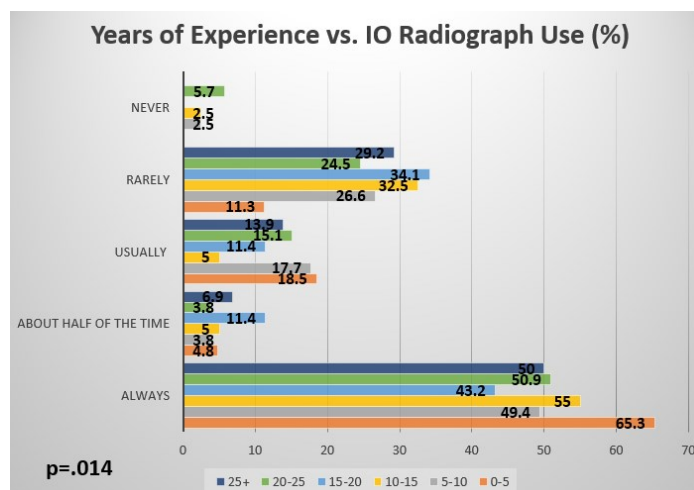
Comparison between years of experience and intra-operative (IO) radiograph use.
